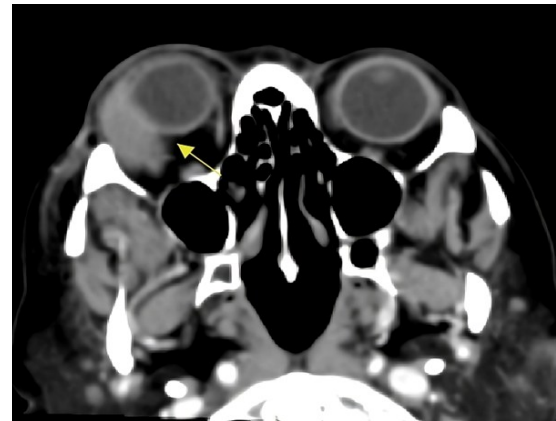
Axial CT scan of the orbits showing a well-defined, extraconal soft tissue mass in the right superotemporal orbit (yellow arrow). The lesion is slightly hyperdense compared to orbital fat and is causing inferomedial displacement of the right globe, suggestive of an orbital mass.
